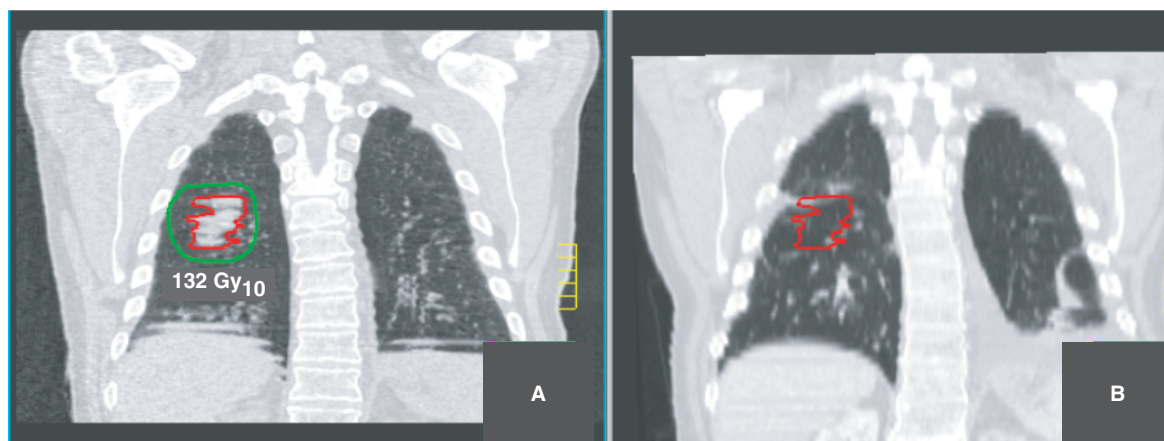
Tumour response to extreme dose-per-fraction escalation. Coronal, in-plane CT reconstructions A) before and B) after (6 months), 5 fractions of 12 Gy each (biologically equivalent dose of 132 Gy), demonstrate a complete response.
